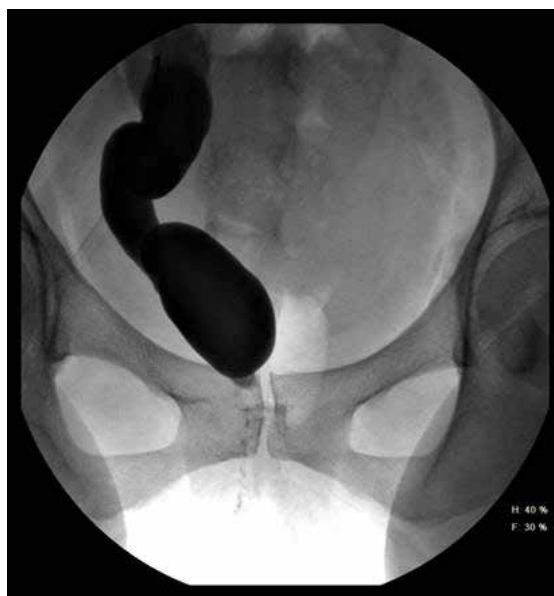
Intrasphinteric urinary leakage shown by contrast CT urography (arrow).
